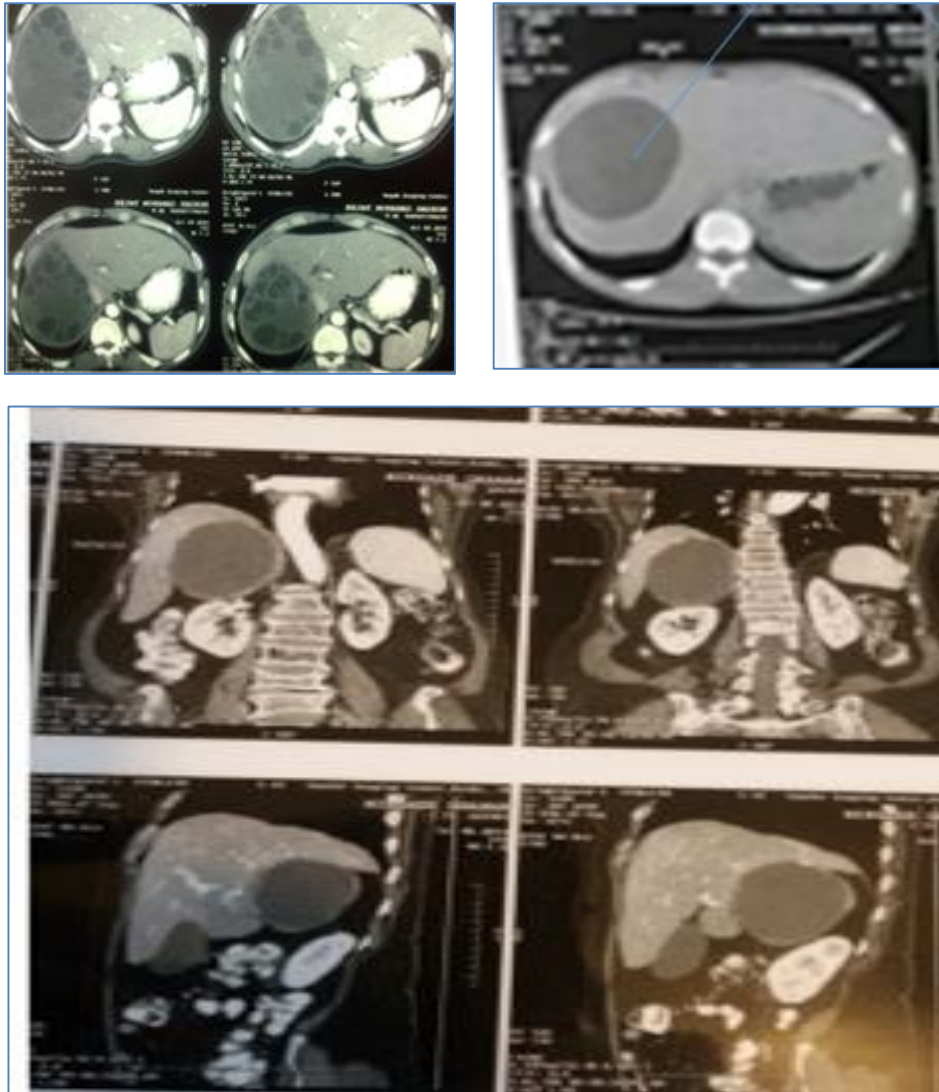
CT and MRI of complicated and uncomplicated liver hydatid cysts
